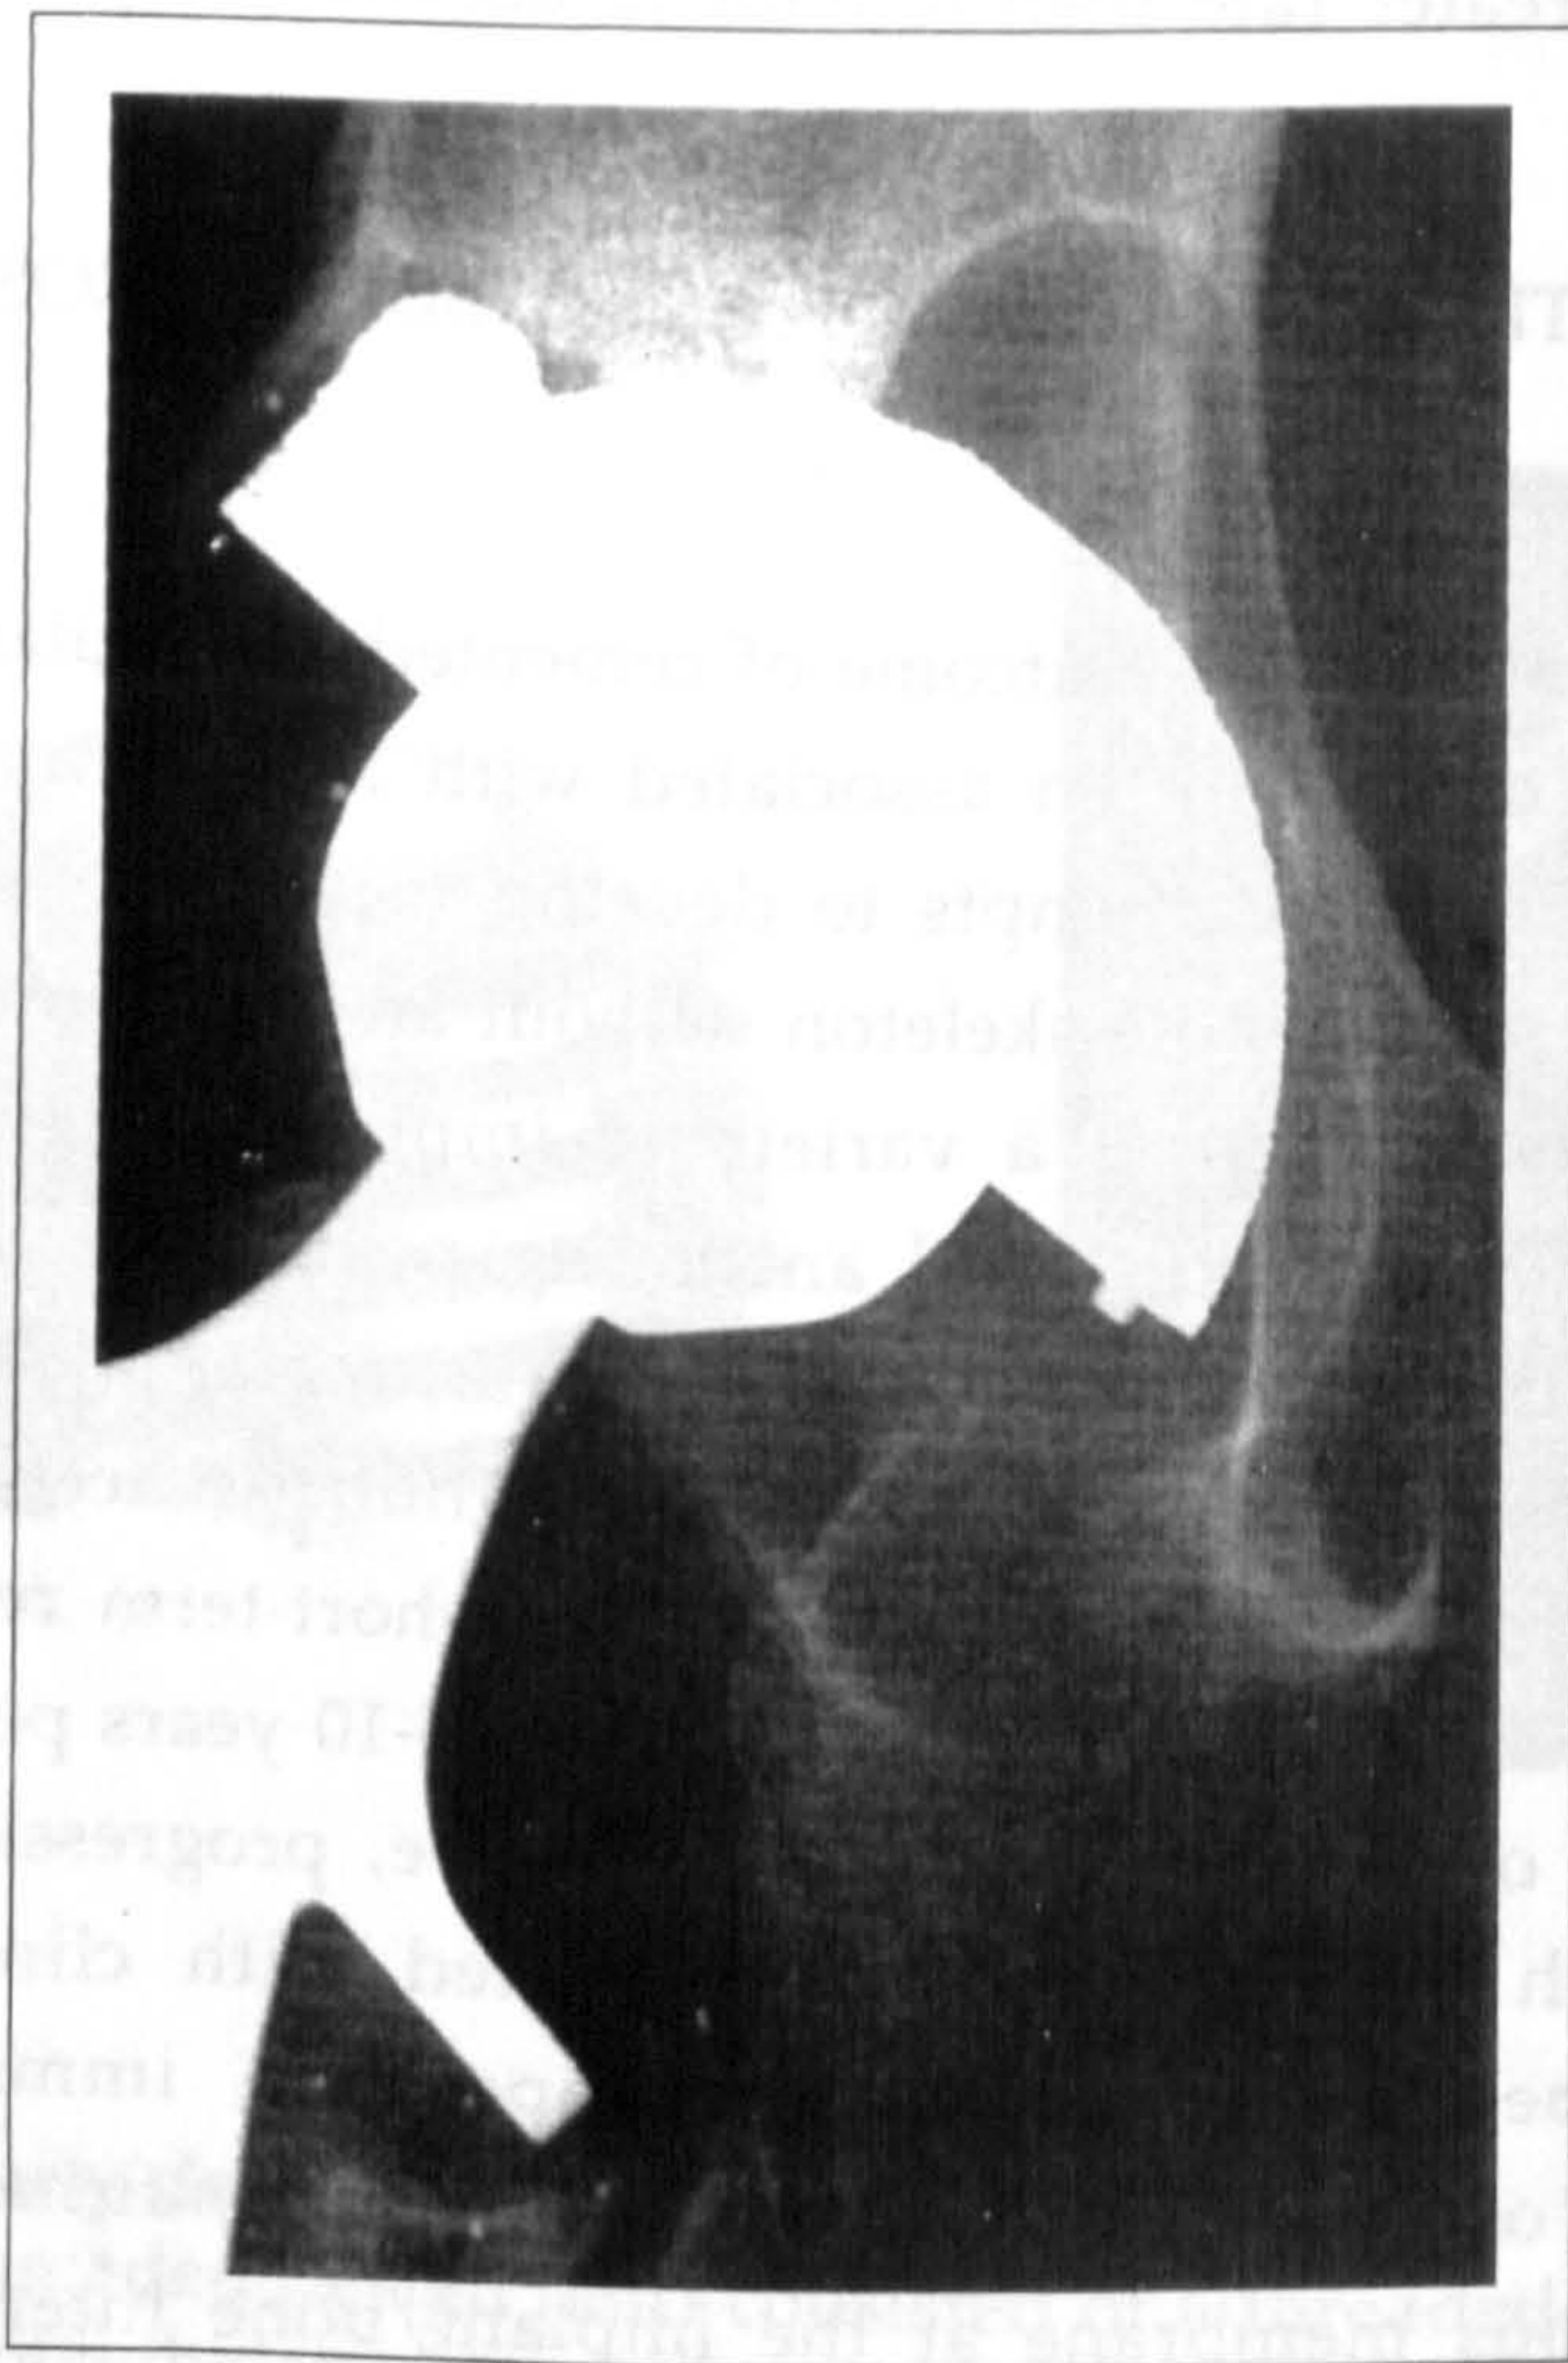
An AP radiograph taken only 3 years after placement of a cementless acetabular cup. A large osteolytic defect is present in the ilium, superior to the acetabular dome. The femoral head is eccentrically located, suggested considerable wear of the UHMWPE.
